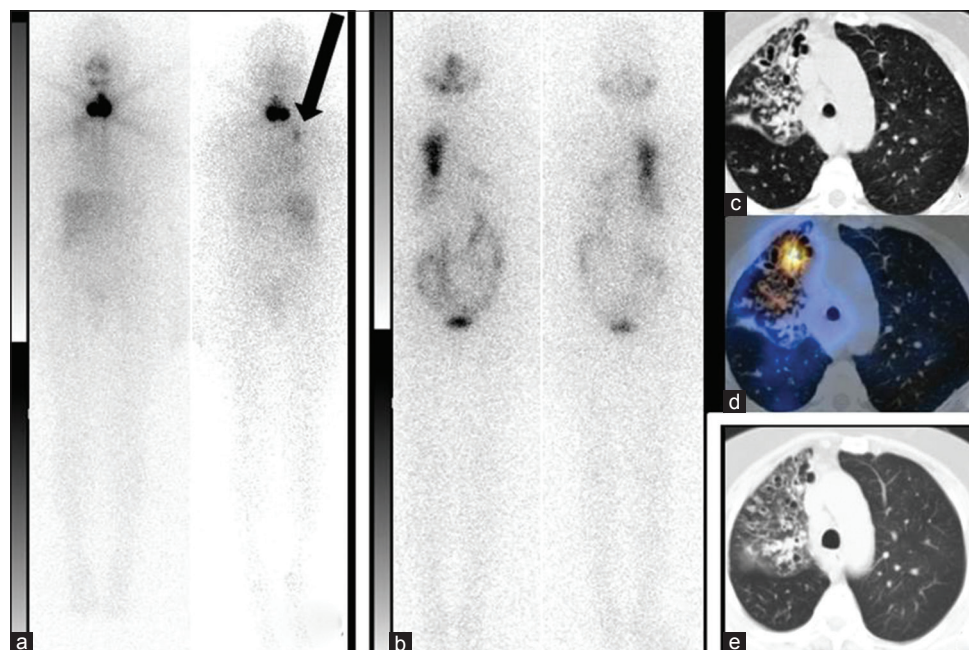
Postoperative ¹³¹I whole-body scan shows tracer uptake in the neck (a) and in the right hemithorax (a, arrow). A following further ¹³¹I whole-body scan confirms diffuse ¹³¹I uptake in the right hemithorax (b); CT (c) and SPECT/CT (d) showed ¹³¹I uptake in association with bronchiectasis in the middle lobe of the right lung. A CT of the thorax (e) performed at follow-up, showed partial resolution of bronchiectasis
